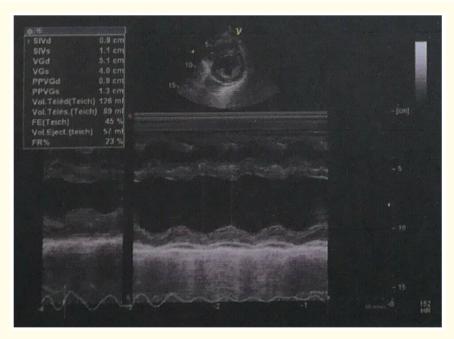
Cardiac echocardiography after 10 days of hospitalization: the left ventricular ejection fraction (LVEF) at 45%.
